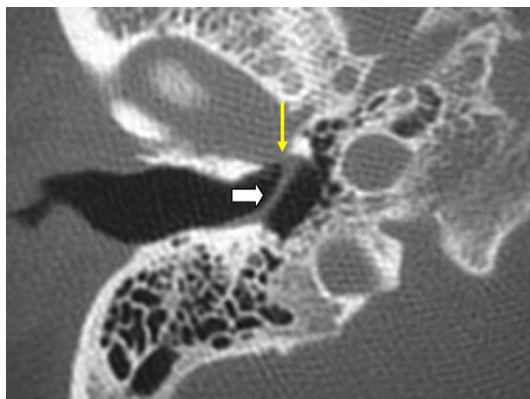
Axial CT image from a patient following transcanal surgery. Note the bone defect in the anterior wall of the EAC (yellow arrow) just lateral to the annulus created during surgery. The TM (white arrow) is diffusely thickened either from scarring, grafting, or myringitis.
